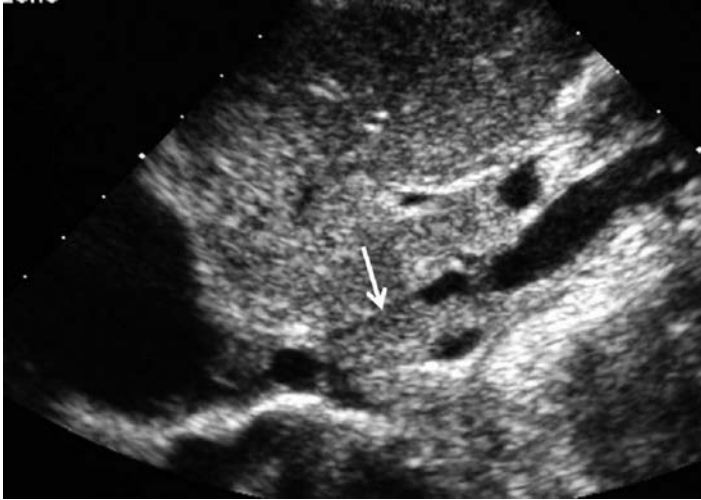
presents Wilms tumor using a sonogram.
